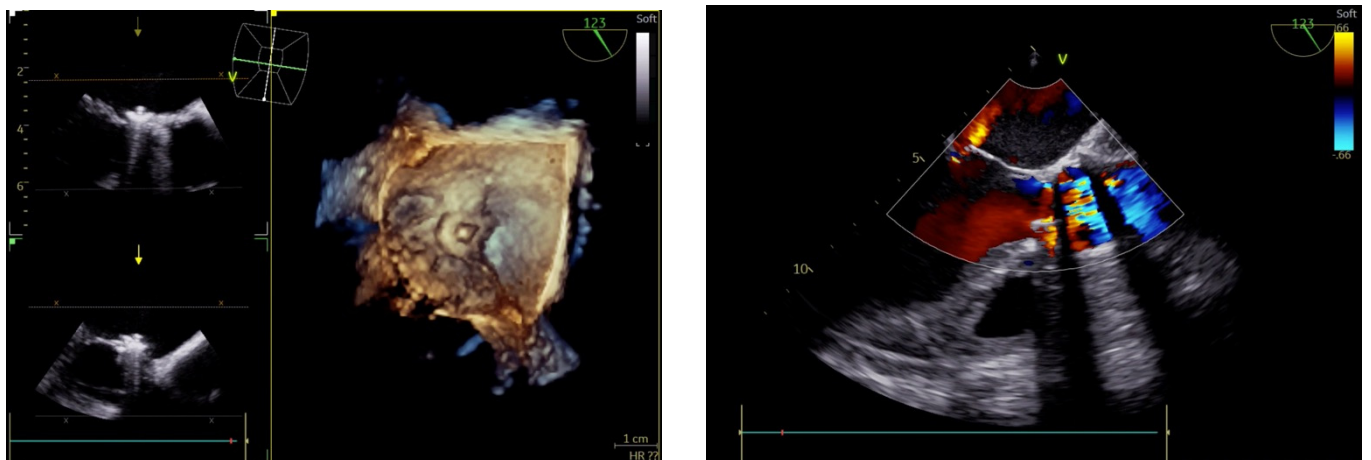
Successful closure of the perforation without a residual regurgitant flow and the Musd occluder (green arrows) are shown both by 3-dimensional and 2-dimensional transesophageal echocardiography.
